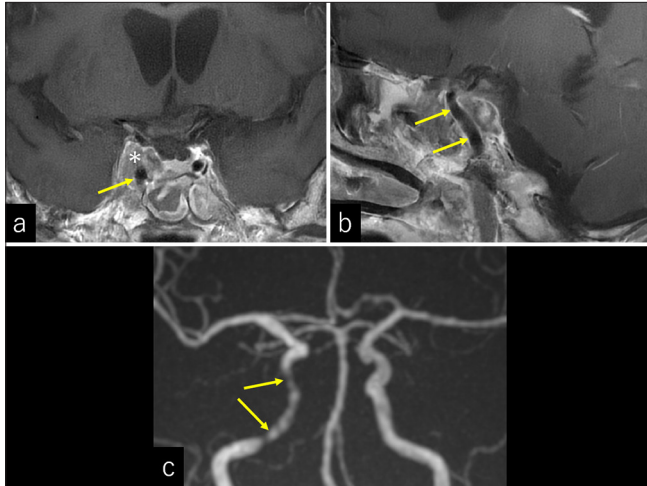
(a and b) Contrast-enhanced (a) coronal and (b) sagittal T1-weighted magnetic resonance (MR) images, performed on postoperative day 21, showing the patent cavernous portion of the right internal carotid artery (arrows). (c) Anteroposterior view of the cerebral MR angiography showing irregular flow in the right C3–C5 segments (arrows), while flows in other segments of the internal carotid, anterior cerebral, and middle cerebral arteries are intact. Asterisk: Residual tumor in the cavernous sinus.
